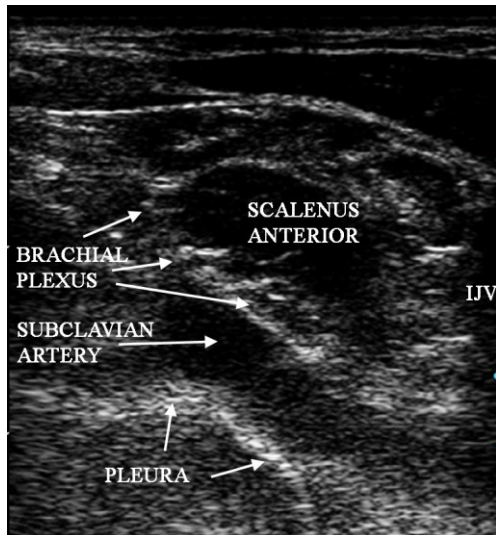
Sonogram of the interscalene groove low in the neck.
